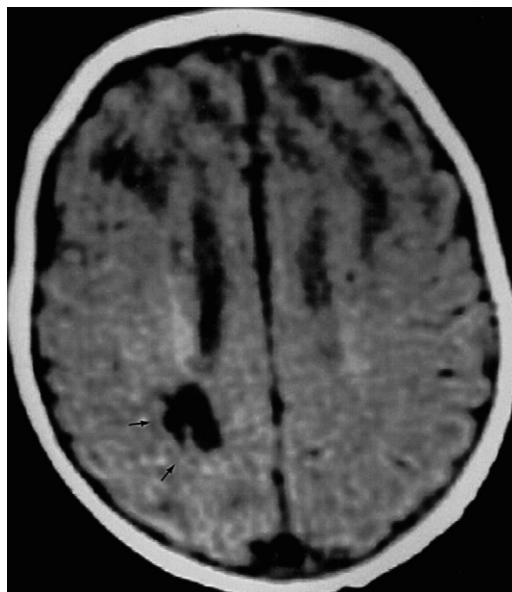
T1-weighted MRI shows recovery of the lesion located nearby right corona radiata and right occipitoparietal subcortical hypointense gliomalacia (arrows).
